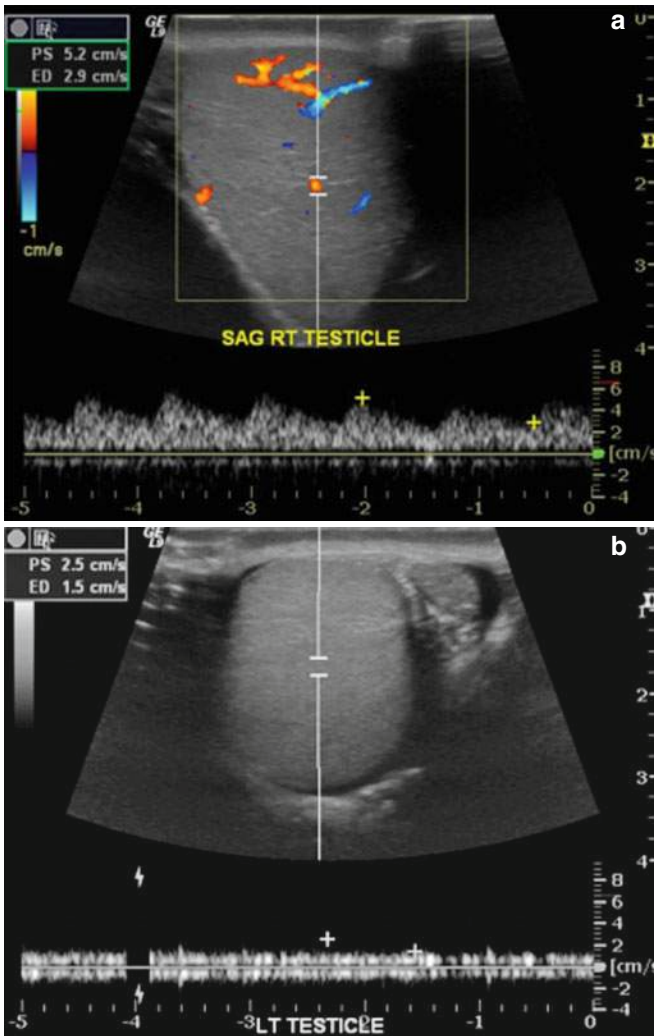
Left testicular torsion. Scrotal ultrasound with Doppler demonstrates pulsatile arterial waveforms in the right (a) but not in the left (b) testicle
